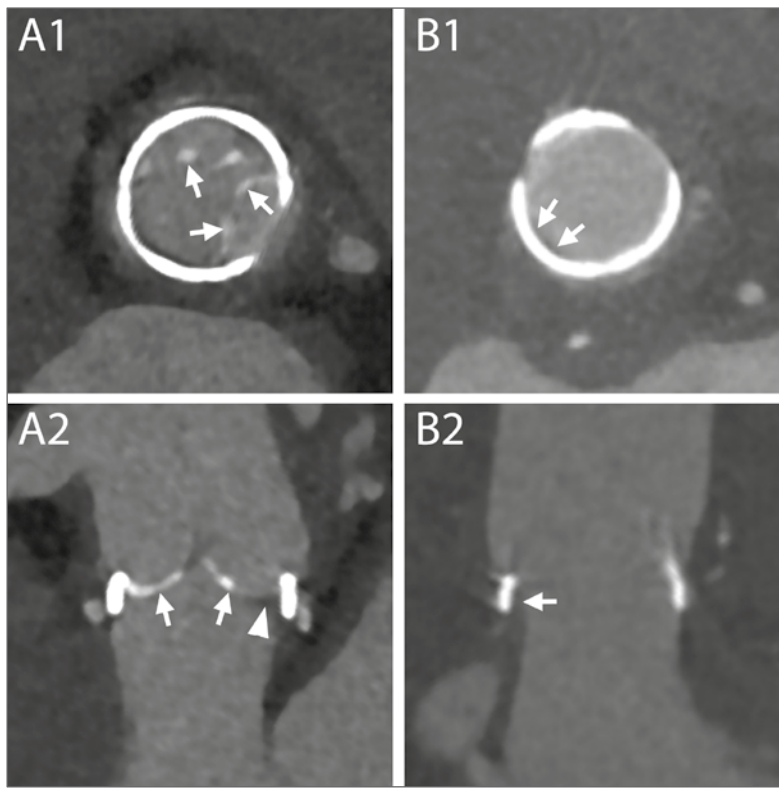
Mechanical alterations to aortic valve prosthesis function. A1-A2 – MPR reconstructions perpendicular (A1) and parallel (A2) to the centerline of the aorta demonstrating calcifications (arrows) and thickening (arrowheads) of the leaflets of a biological valve implanted 7 years before this scan in a 37-year-old man. The degeneration of the leaflets caused a severe, although asymptomatic, stenosis (4,5m/s at echo) and the valve was replaced a few months later. B1-B2 – A follow-up CT scan in a 81-year-old woman revealed the presence of a thin rim of hypodense material (arrows) adjacent to the ring of this biological valve, which was implanted 4 months before, on both MPR reconstructions perpendicular (B1) and parallel (B2) to the centerline of the aorta. Although an infectious origin could not be ruled out with certainty based solely on CT characteristics, the laminated and smooth aspect of the material along the contour of the metallic ring indicated that it should more likely be ascribed to thrombus/pannus.
